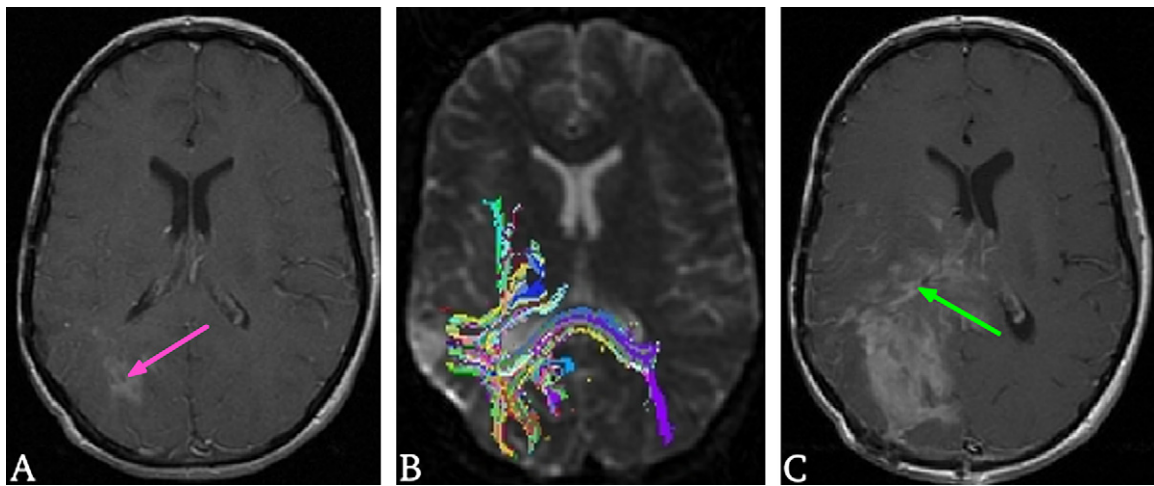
(A) T1-weighted post-contrast image showing an astrocytoma (pink arrow). Surgical resection of the primary tumor occurred more than 2 years before the image (A). (B) Diffusion tensor imaging reference image ($b = 0$) take at the same time point (A), showing all diffusion paths passing through the tumor, the splenium of corpus callosum, and the internal capsule. (C) T1-weighted postcontrast image acquired 2 months after the time point (A) showing progressive disease (green arrow) having spread along the internal capsule and splenium of corpus callosum (B).
